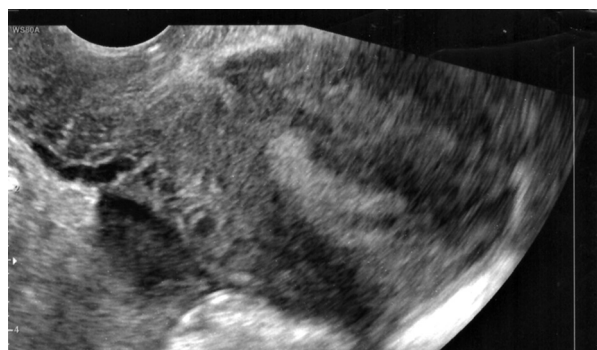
Transvaginal ultrasound three months after surgery shows a normal finding of the uterus without pathological changes
